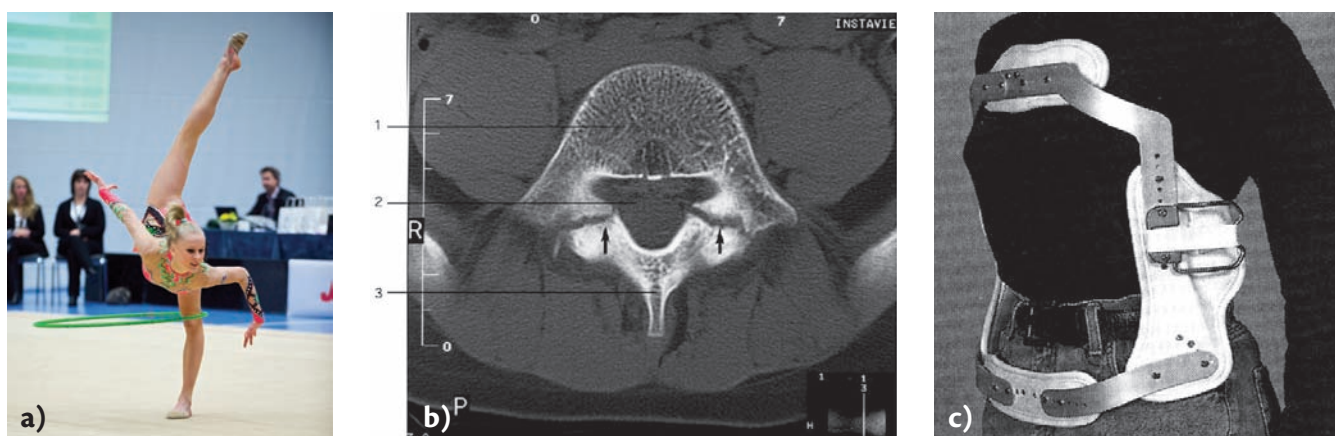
Defective vertebral arches – spondylolysis may occur as a stress fracture. a) Gymnast in extreme positions, such as backward bending of the spine, are at risk of overloading the vertebral column with stress fractures as a result; b) spondylolysis of the fifth lumbar vertebra (L5) verified with computed tomography (CT) caused by fatigue of the skeleton, i.e. stress fracture in the vertebral arch (see arrows). 1: Vertebral arch; 2: vertebral foramen; 3: transverse processes; c) a Boston brace used for fixation of stress fractures of the lumbar spine. (Courtesy of Prof. Tommy Hansson, Sahlgren Academy, Gotheburg University, Göteborg, Sweden.)
